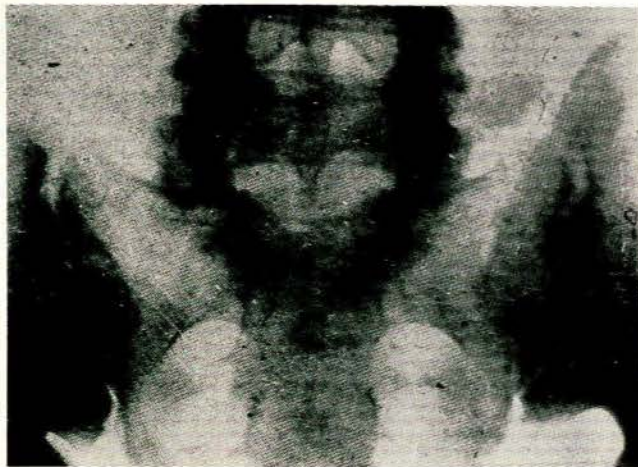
Photograph of X-rays showing changes of ankylosing spondylitis of the left sacro-iliac joint.
